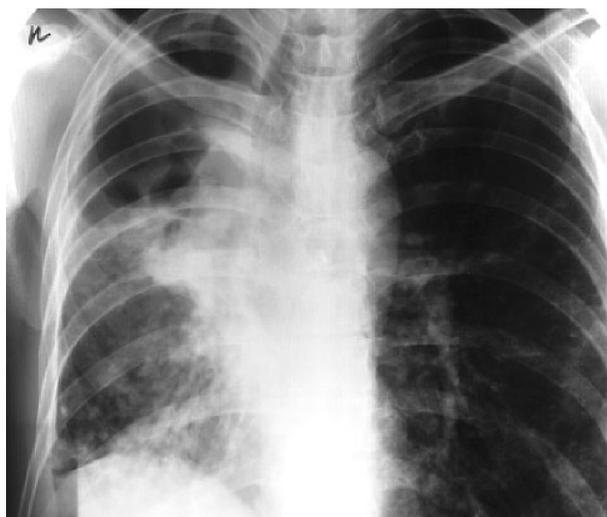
Chest X-ray after 4 month
